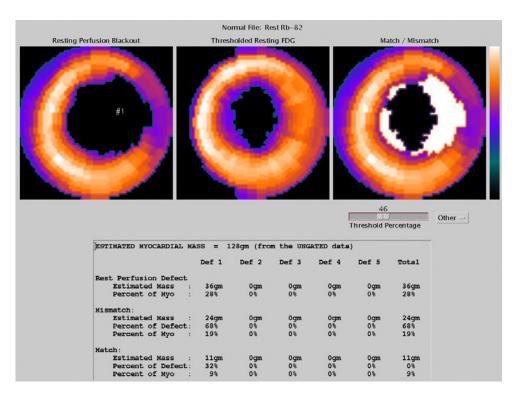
Estimated match/mismatch between raw FDG and rest perfusion..
